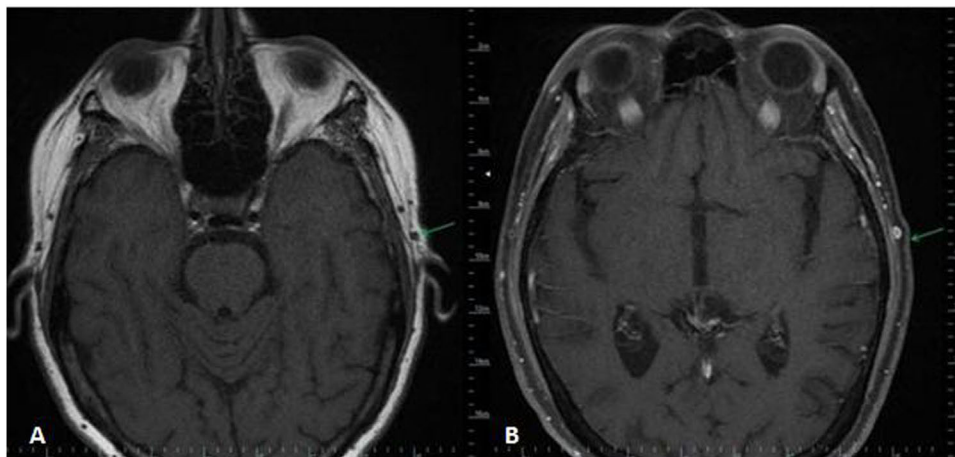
A, Axial T1 precontrast magnetic resonance imaging (MRI) demonstrating thickening of the left superficial temporal artery with central hypodensity demonstrating the flow void in signal in comparison with contralateral normal-sized superficial temporal artery. B, Axial T1 postcontrast MRI demonstrating enhancement of the left superficial temporal artery.
